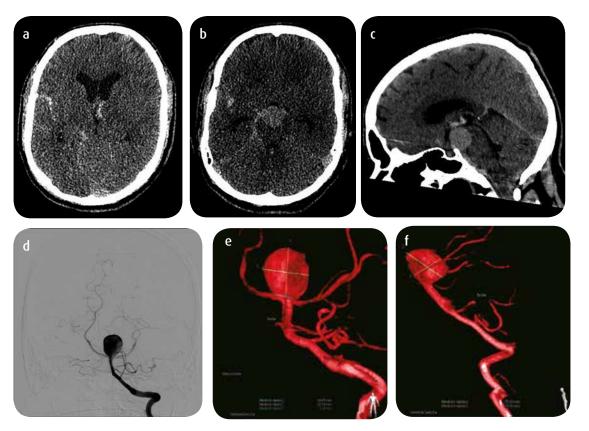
Male patient, 47 years old. History of heavy smoking. Consultation for severe headache. WFNS grade I. a and b) axial single skull CT: modified SAH Fisher grade 2. c) Sagittal: compatible image with basilar aneurysm. d, e and f) Arteriography: confirms broken giant aneurysm of the basilar top, 25 mm in diameter, with a broad neck of 7 mm. The patient did not develop vasospasm in serial transcranial Doppler controls.
